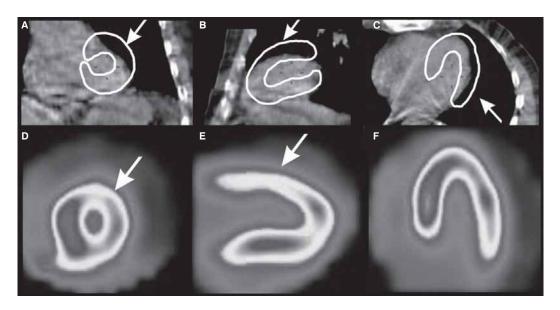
Example of an artifact caused by misalignment between SPECT and CT studies. CT tomograms in three planes with contours of left ventricular myocardium and attenuation corrected scintigrams. Arrows show overlapping of anterior and lateral walls on the lung area and artifacts on scintigrams caused by erroneous attenuation correction. A. Fused coronals; B. Fused sagittals; C. Fused transaxials; D. Attenuation corrected (AC) SPECT — short axis; E. AC SPECT — vertical axis; F. AC SPECT — horizontal axis.
